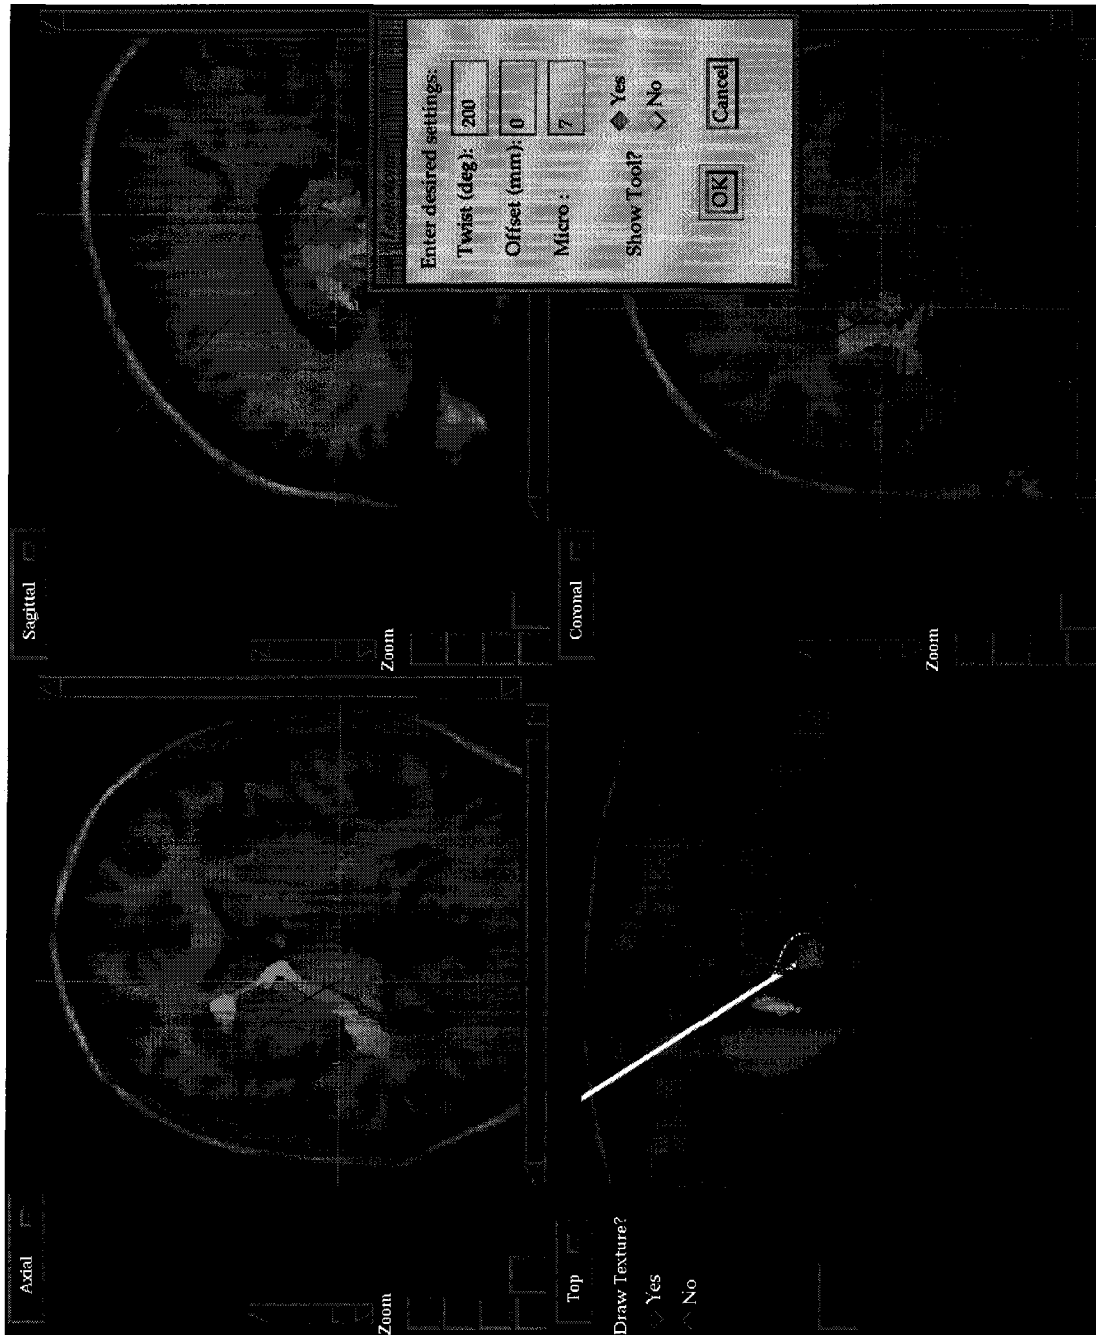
A screenshot of the IGNS Laboratory surgical guidance software (VIPER) displaying the Schaltenbrand and Wahren atlas overlaid on an MRI. The trajectory and position of the leukotome is also modelled. The bottom-left panel shows surface-renderings of some deep brain nuclei, including the thalamus (red mesh) and the *vim* (green).
